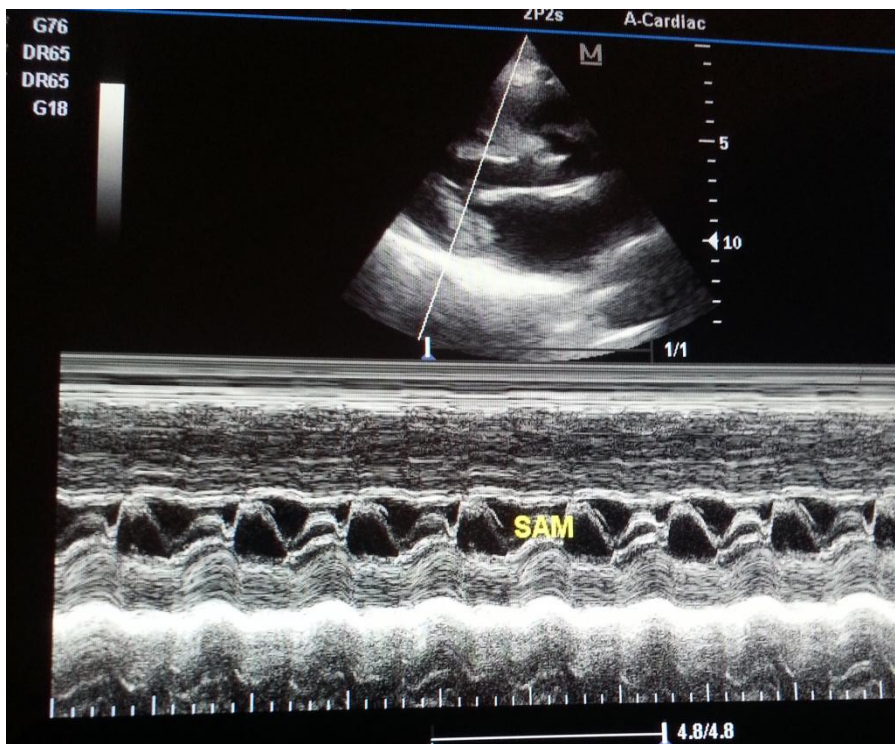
2D guided M mode echocardiogram of Case 2 also showing SAM.
